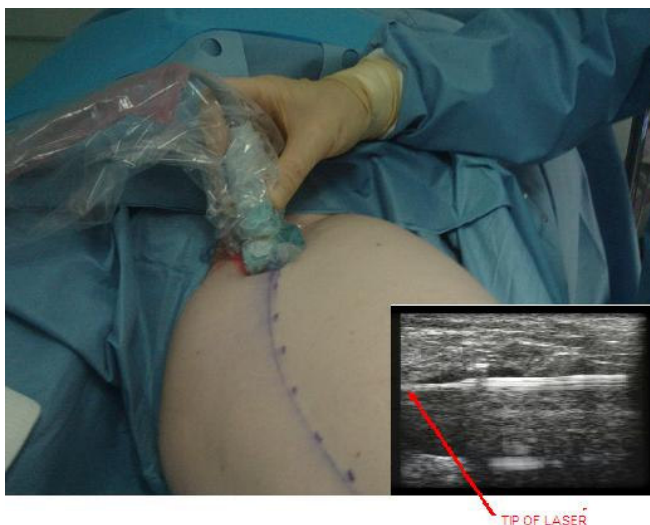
EVLA under ultrasound control
